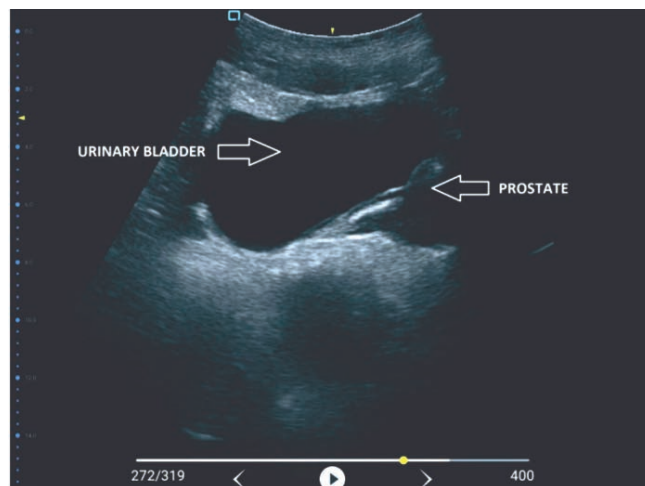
Pelvic ultrasound image from the sagittal position
